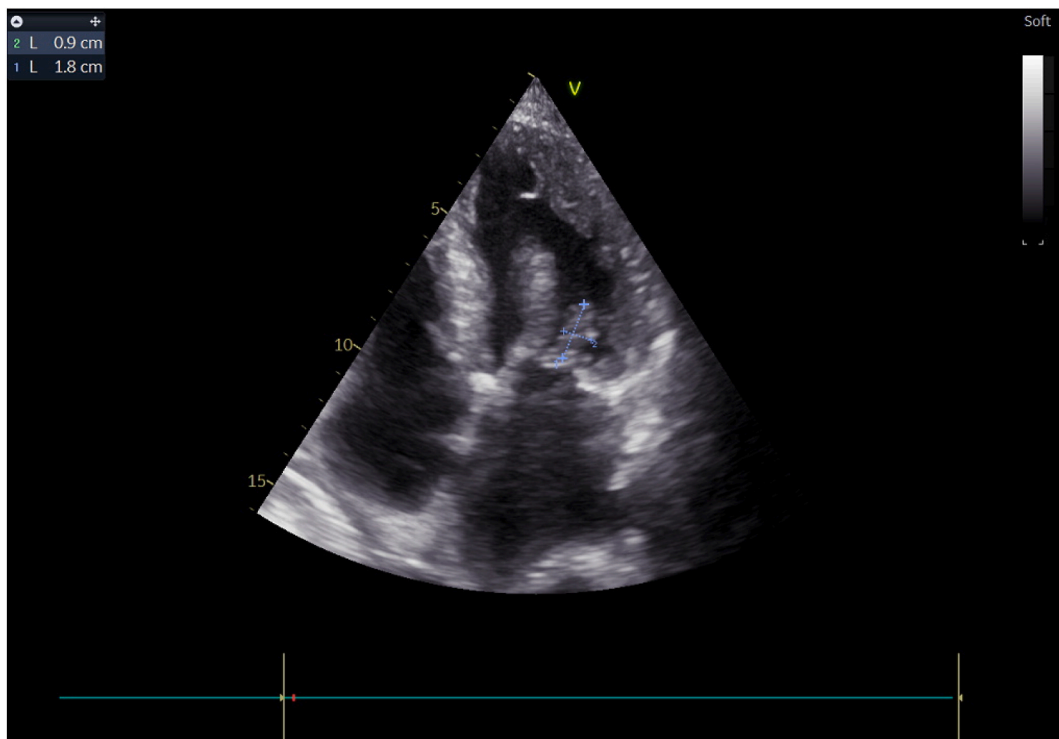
Four cavities view with transthoracic echocardiography showing the mitral vegetation.
